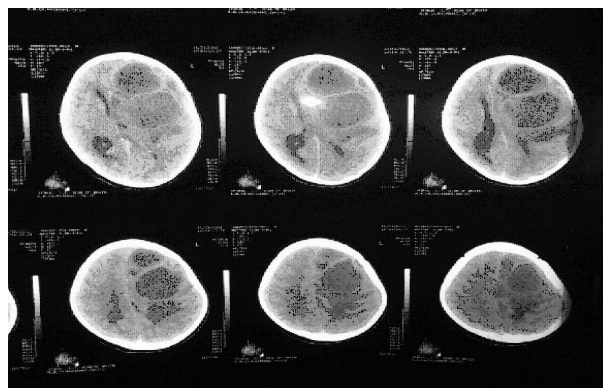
(a, b): CT scan of brain shows two abscess on left side with perifocal oedema and midline shift.
